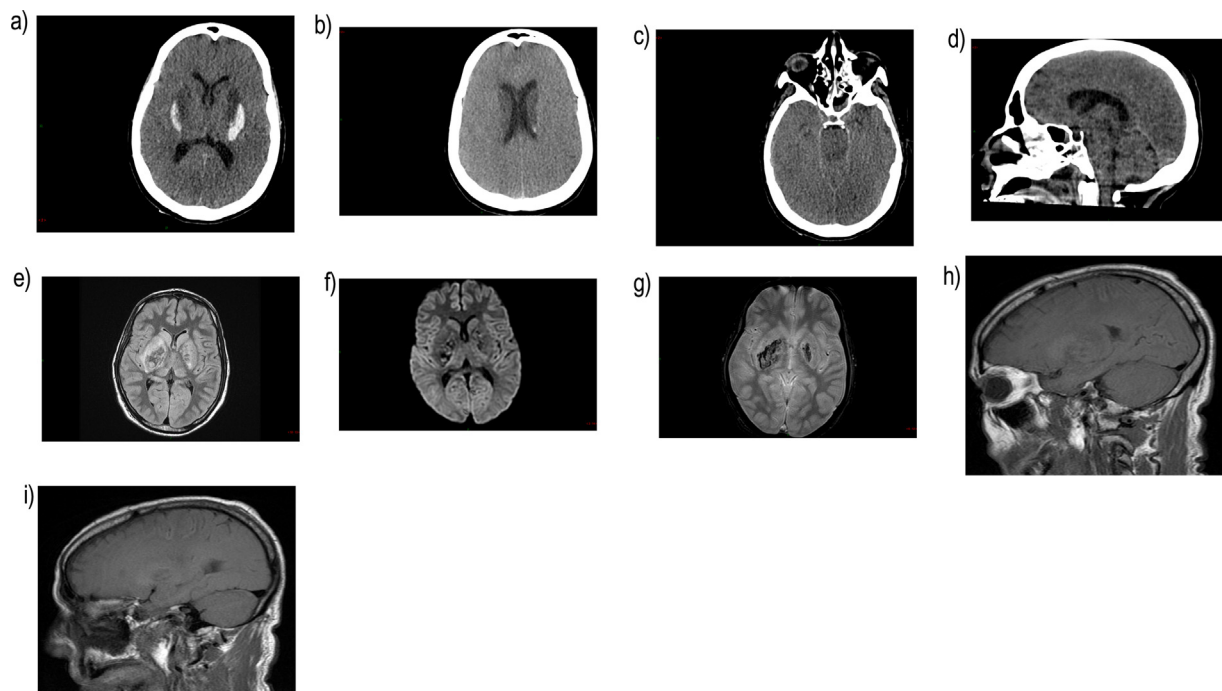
Case 1: Non-enhanced CT at day 2 after CA shows: bilateral hemorrhagic infarct at the external and posterior part of both putamen and profound hypodensity of the anterior part of both putamen, of both pallidi and caudate nuclei (CN) (a), petechial hemorrhage in the corpus of the right CN (b) and marked hypodensity of the tectum of the mesencephalon (c), well visualized on Sagittal reconstruction (d).
